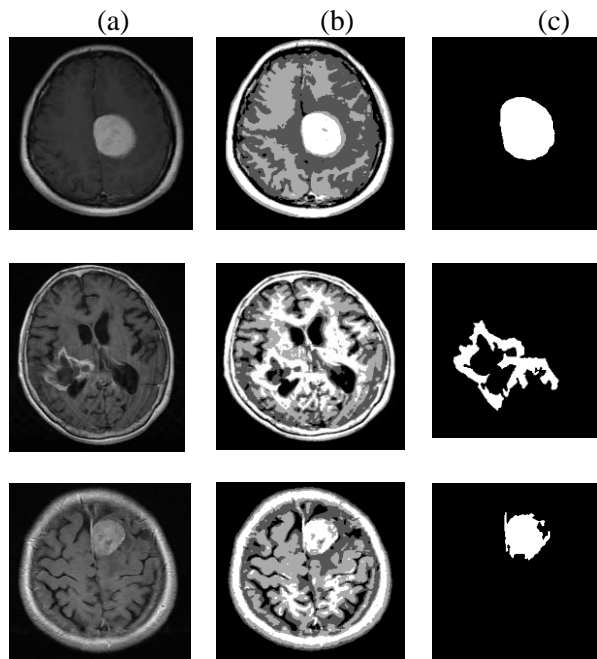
(a) T1W1 Sliced input brain MRI (b) ARKFCM Segmented brain tumour images (c) Region of Interest obtained using ARKFCM
